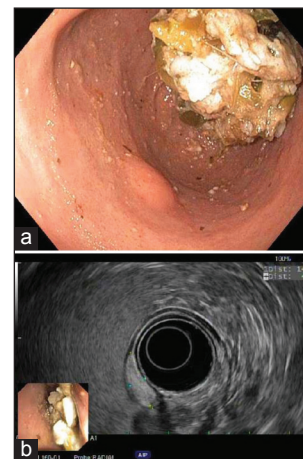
Gastric lipoma. (a) Endoscopic image; (b) Endoscopic ultrasound images
